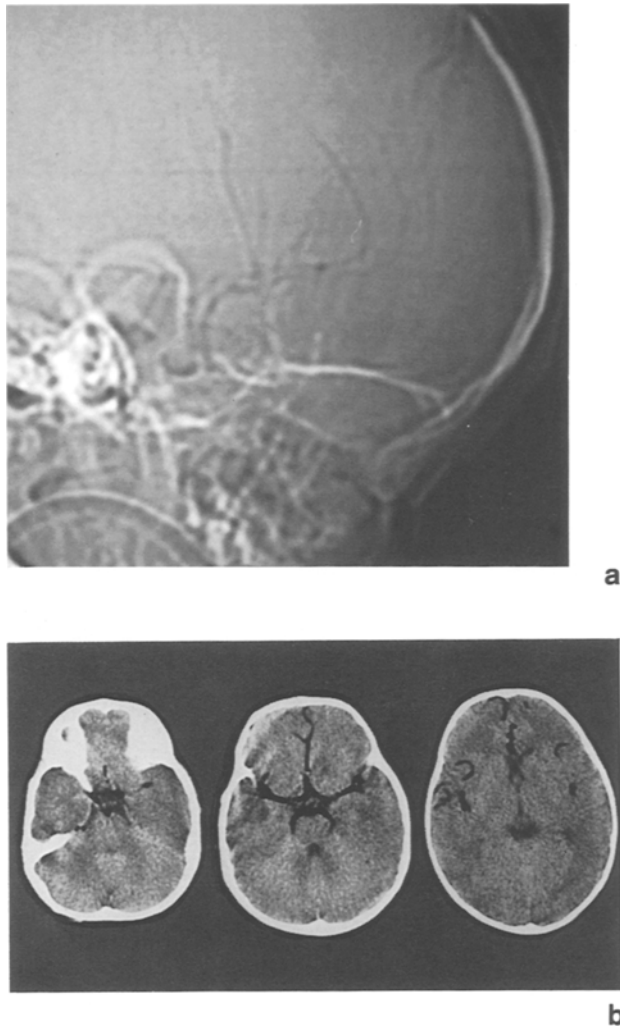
(a, b) Case 2. A CT scan of the head half an hour after admission showed diffusely air-filled main trunks of the anterior and middle cerebral arteries
